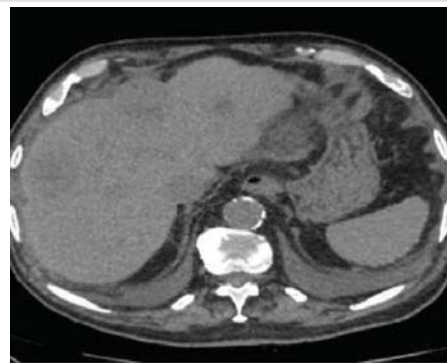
Abdominal CT scan showing liver metastasis
